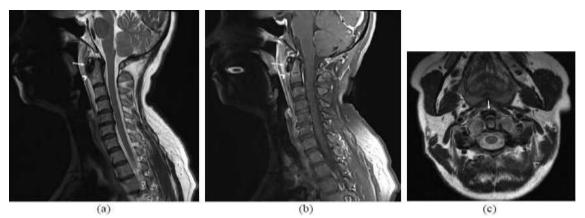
Initial C-spine MRI. a. Contrast enhanced T1W sagittal view. b. T2W sagittal view. c. T2W transverse view. There is a severe prevertebral soft tissue swelling (arrowhead) without evidence of abscess or inflammation, and proximal fibers of the longus colli tendon have calcification (arrow).
